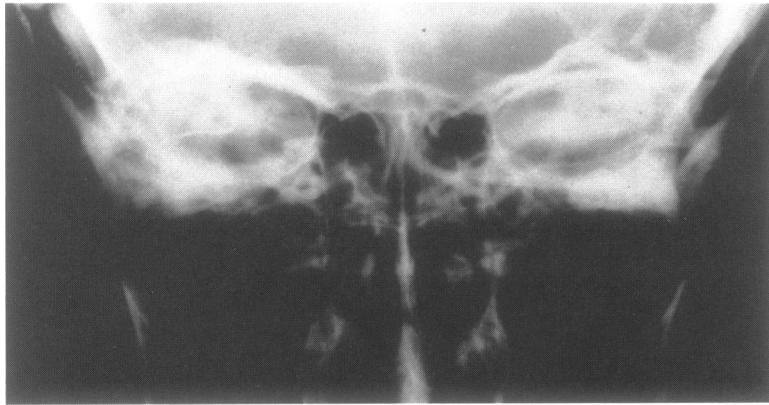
Transorbital X-ray of patient 1, 12 months later. A cochlear implant was reimplanted successfully.
